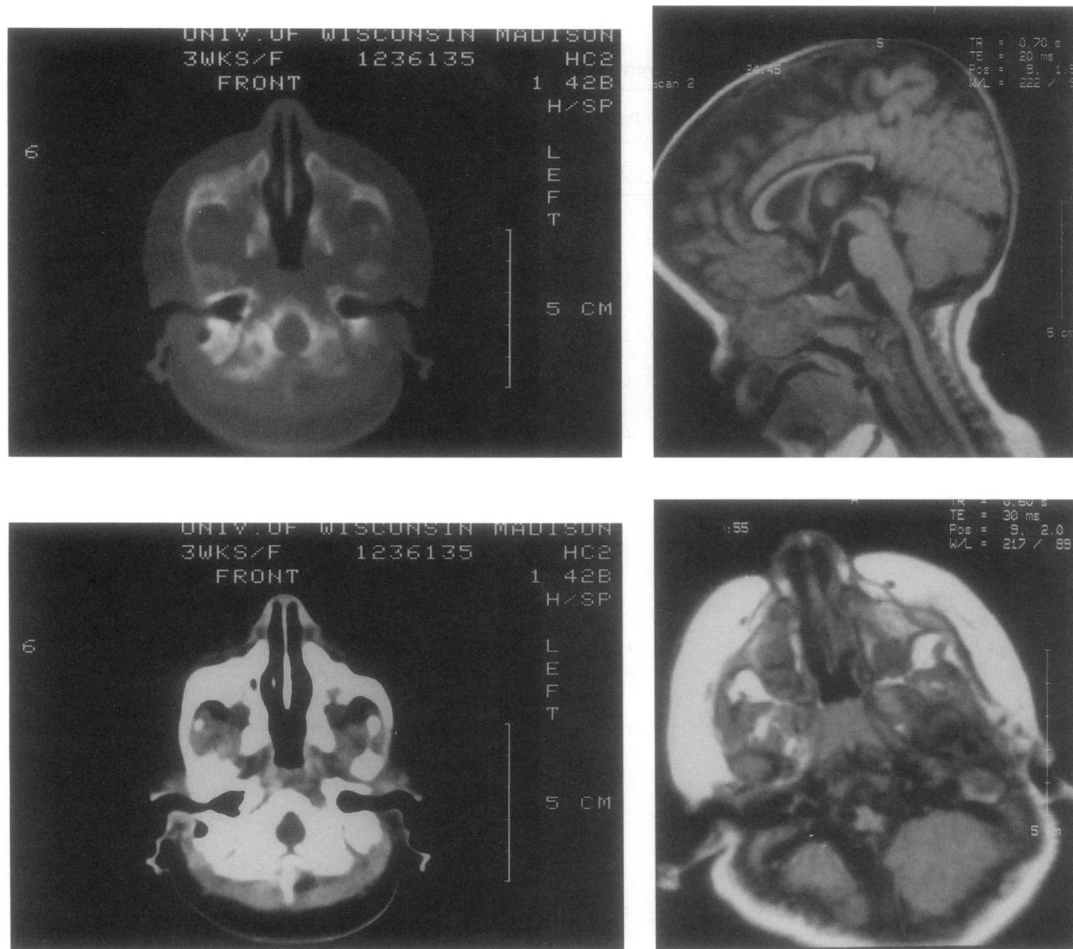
Computed tomography (left, with bone windows shown in the lower panel) and magnetic resonance imaging (right) of the foramen magnum of example 1, demonstrating constriction of the foramen and deformation of the upper cervical cord as described in the text.
